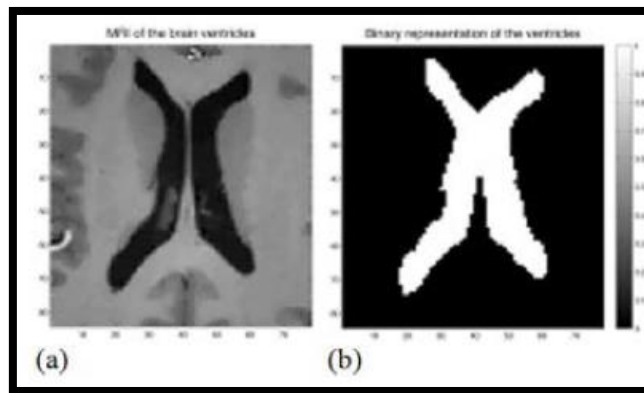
An example of an MRI image before (a) and after(b) thresholding has been applied(1).
